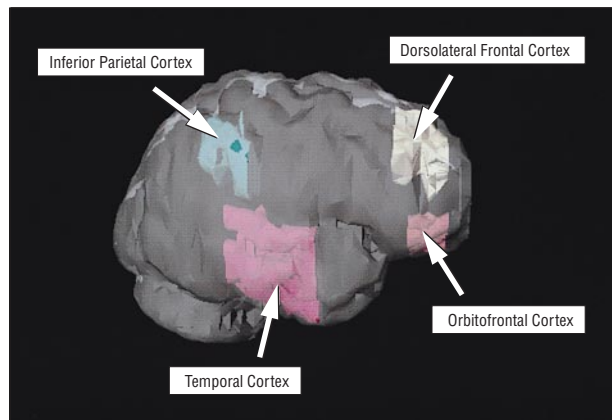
Volumes of interest from a single control subject, shown as projected onto a model of the brain surface derived from the subject's magnetic resonance image. For clarity, medial cortical regions (hippocampus, calcarine cortex) are not shown.
